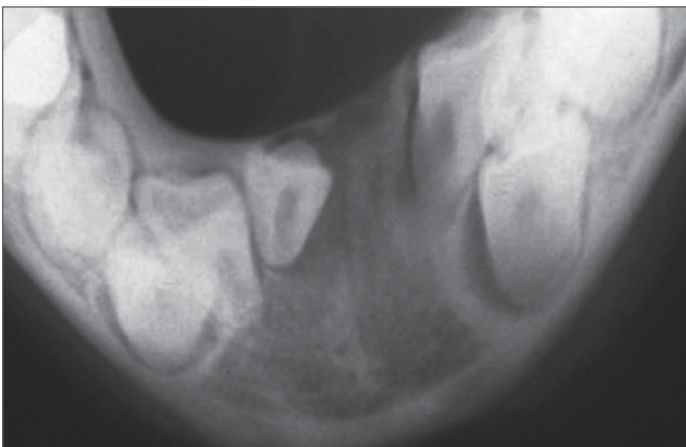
Mandibular occlusal radiography reveals lingual expansion of the cortical bone.
